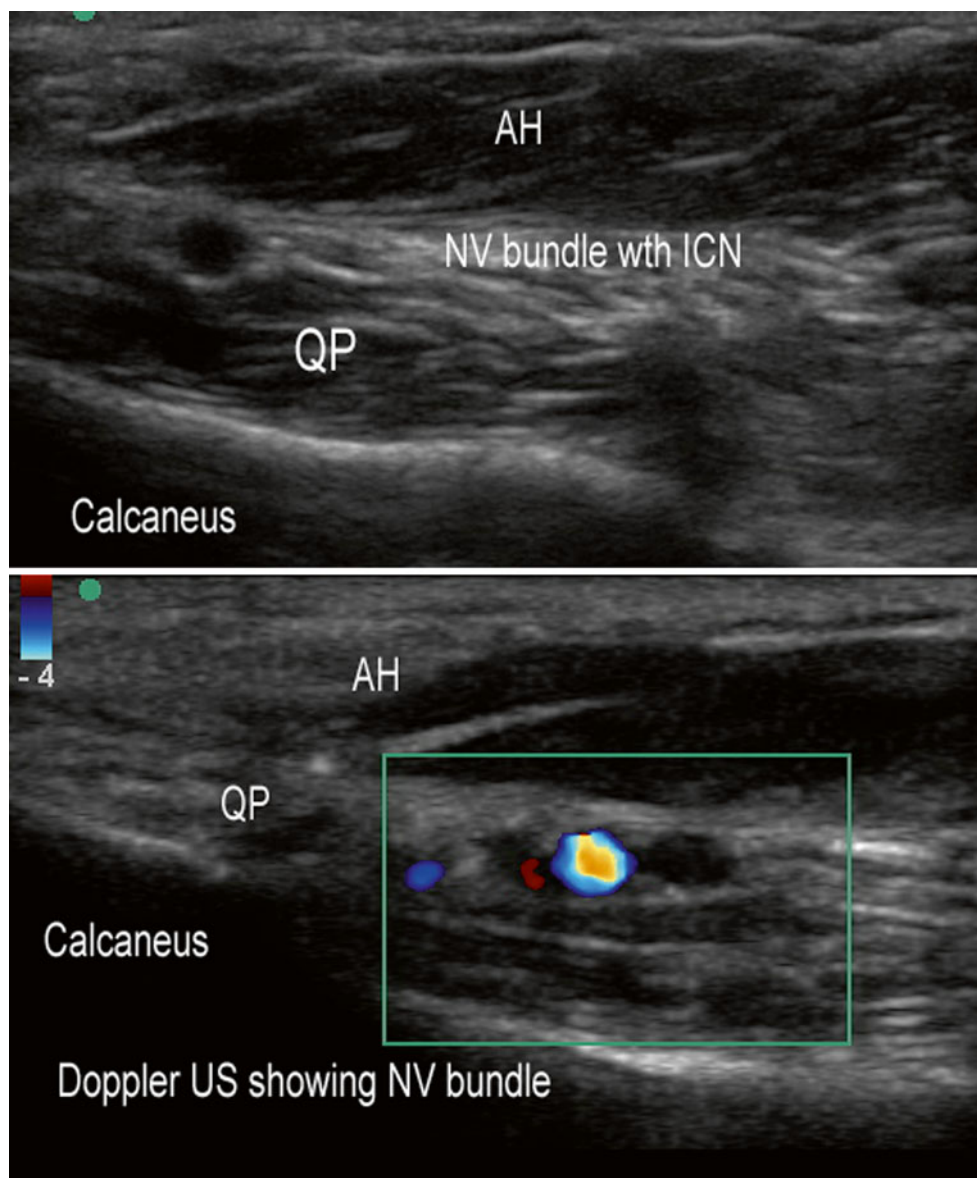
In-plane ultrasound image showing the probe location and the neurovascular bundle that includes the inferior calcaneal nerve. *AH* abductor hallucis muscle, *QP* quadratus plantae muscle, *ICN* inferior calcaneal nerve (Image courtesy of Michael Brown, MD)
